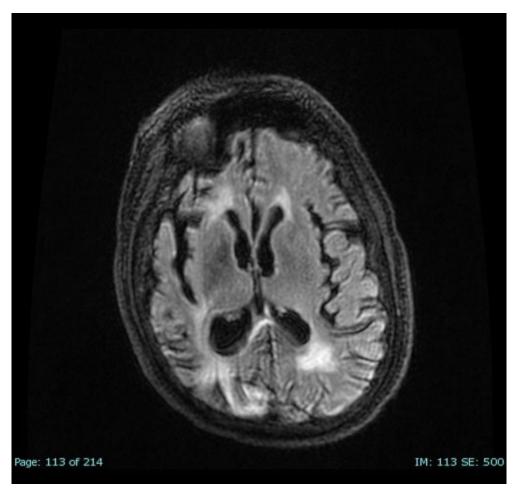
T2 FLAIR revealing extensive atrophy bilateral hemisphere with bilateral medial temporal atrophy and enhancement.
